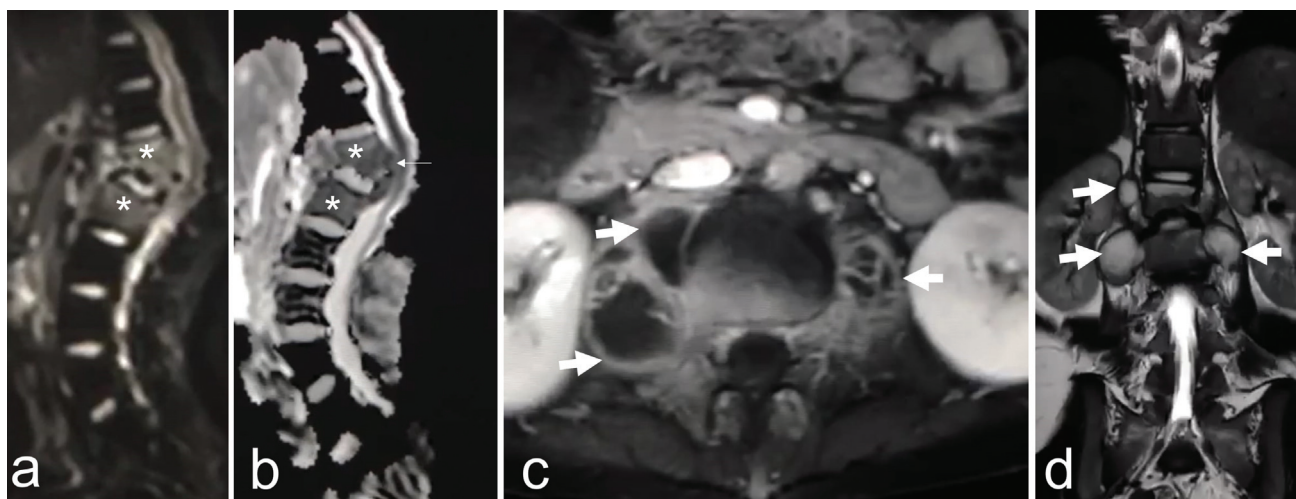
A 12-year-old girl with painful progressive kyphosis. Sagittal (a) diffusion-weighted image (DWI) ($b = 500$) and (b) corresponding apparent diffusion coefficient (ADC) map, (c) transverse contrast-enhanced fat-suppressed T1-weighted images, and (d) coronal T2-weighted images show abnormal restricted diffusion of T12 and L1 vertebrae (asterisks) with epidural extension (b, arrow) and paravertebral peripherally enhancing collections with low T2 rim (c, d, arrows). The patient was found to have tuberculous spondylitis. The usefulness of ADC values in differentiating malignancy from infection is not consistent (courtesy of Joseph El-Khalil, MD, Beyrouth, Lebanon).
